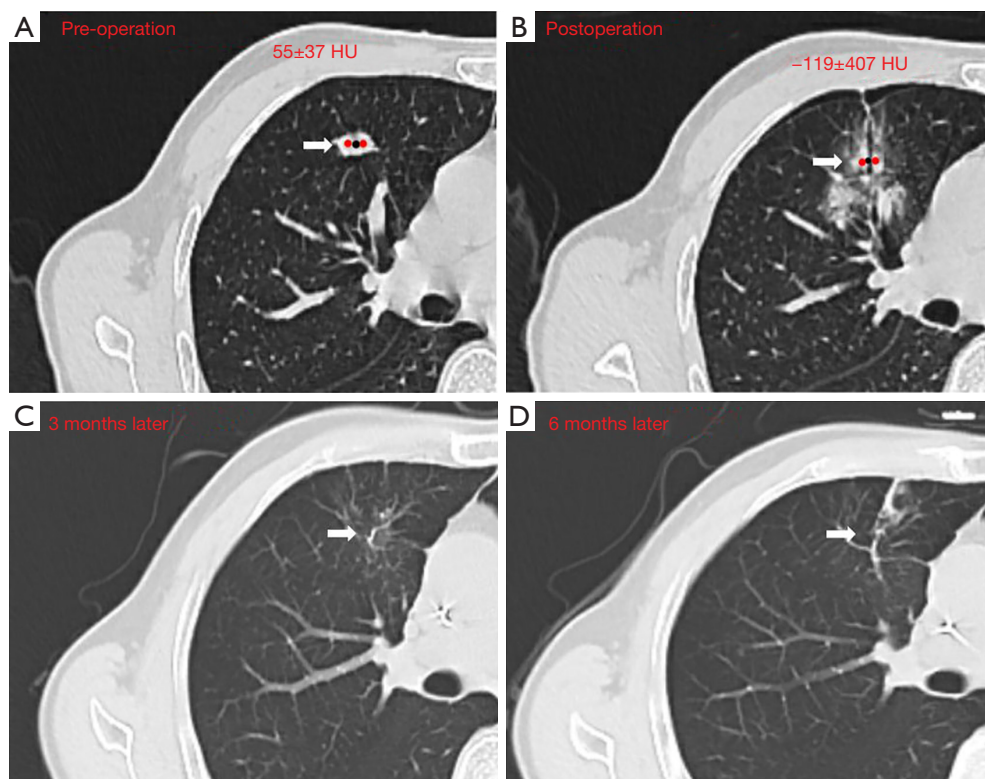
A 61-year-old male patient with sigmoid carcinoma with lung metastasis: (A) the average CT value at the measurement points before ablation was 55 ± 37 HU; (B) the average CT value at the measurement points after ablation was -119 ± 107 HU; (C) CT reexamination 3 months after surgery showed fibrous strips in the ablation lesions; (D) CT reexamination 6 months after surgery showed fibrous strips in the ablation lesions. The red dots represent the tumor center, while the black dots on either side indicate CT value measurements in (A,B). The arrow indicates the focal area of the tumor. HU, Hounsfield unit; CT, computed tomography.
